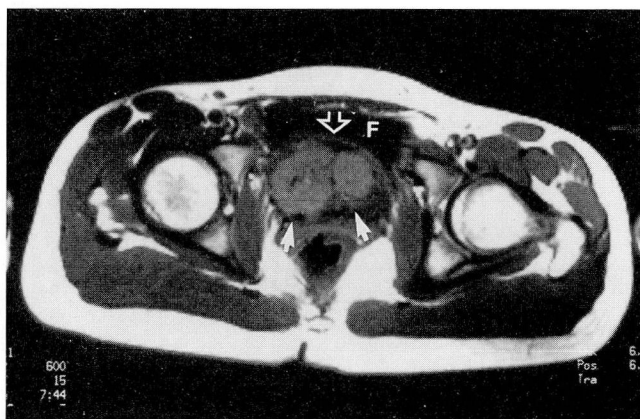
Axial T1-weighted (TR 400 msec, TE 15 msec) MR image corresponding to level through mass on CT (Figure 1). Fluid (F) in bladder is black. The mass (white arrows) is lobulated and displaces the bladder wall (open arrow), represented as a uniformly thin band anterior to mass.
